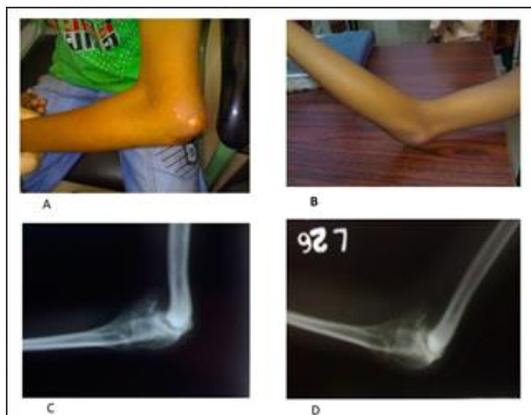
A. Clinically possible flexion. B. Clinically possible extension. C. X-ray in flexion at non-union site. D. X-ray in extension at non-union site.
